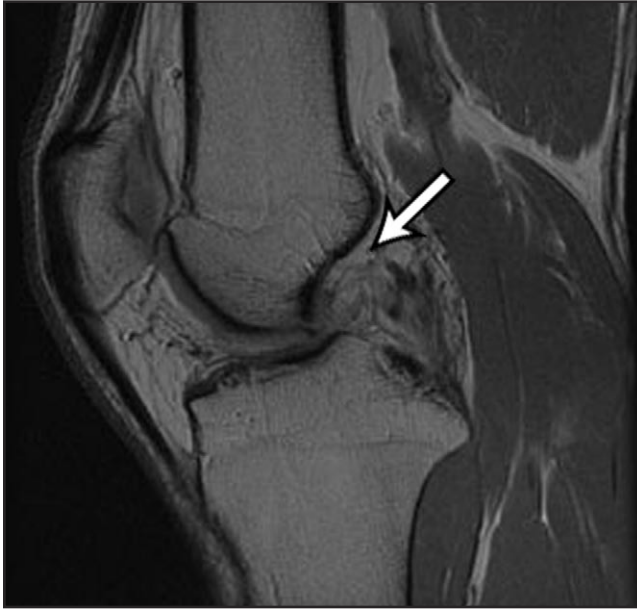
This T2-weighted MRI demonstrates a chronic grade III tear of the posterior cruciate ligament (PCL). The proximal stump of the PCL is indicated by the *arrow*.
